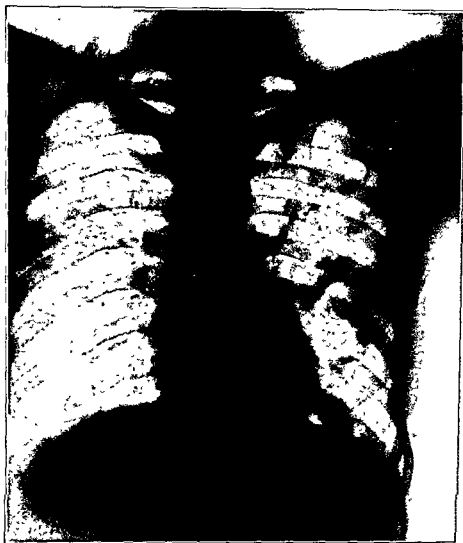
An x-ray of a check-valve cavity. Note the spherical appearance of the cavity in the left upper lobe. There is a small amount of fluid at the bottom of the cavity. There has been no displacement of the trachea and mediastinum. There has been no narrowing of the intercostal spaces. The bronchi leading to the cavity are accentuated. See Figs. 43 and 44.
